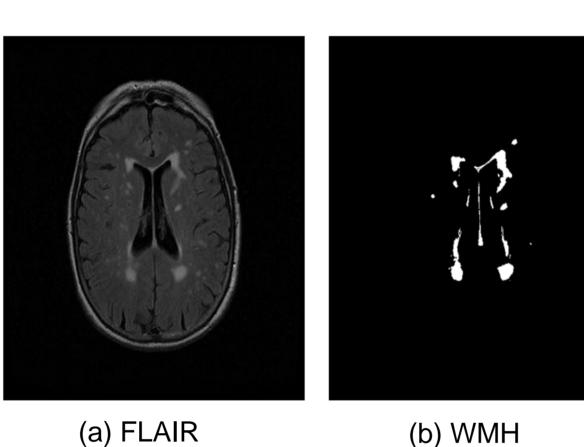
Segmented WMH from FLAIR image using fuzzy connectedness algorithm
